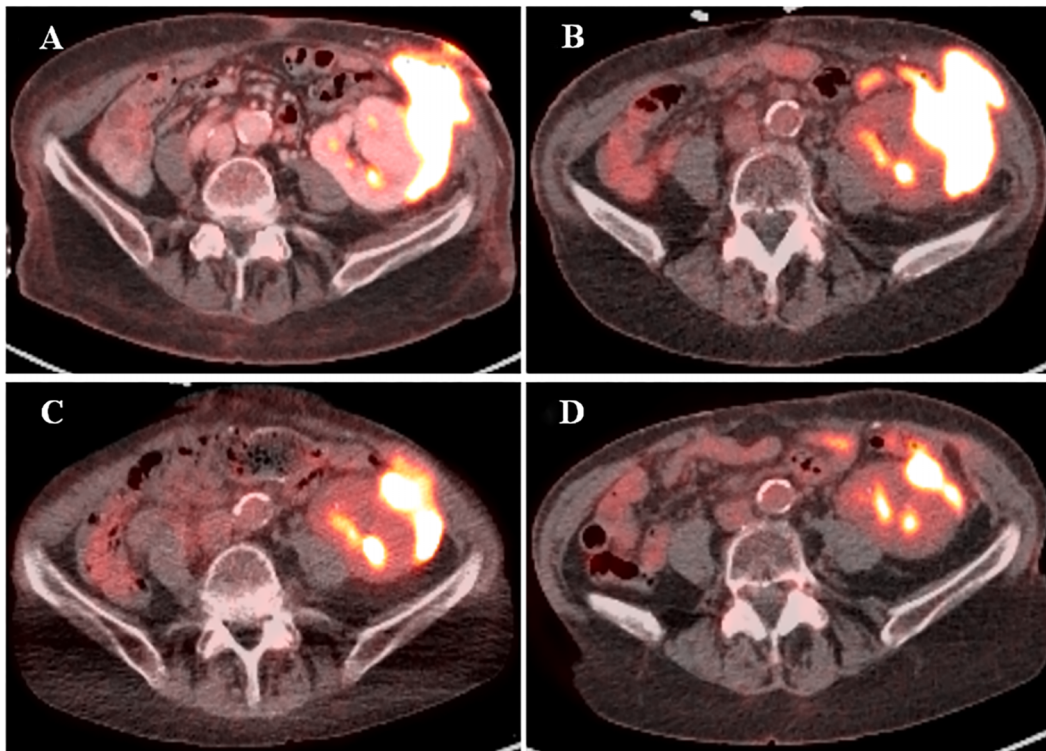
Evolution of renal allograft malakoplakia by FDG-PET CT imaging. (a) On 5 November 2024, initial presentation: baseline. (b) 10 December 2024, after 5 weeks of antibiotic treatment, resulting in a resolution of skin involvement. (c) 10 February 2025, after 14 weeks of antibiotic treatment, resulting in a significant reduction of the metabolic mass. (d) 2 May 2025, 26 weeks after initial presentation and 11 weeks after antibiotic cessation, further reduction of the metabolic mass with resolution of the abdominal wall infiltration.
